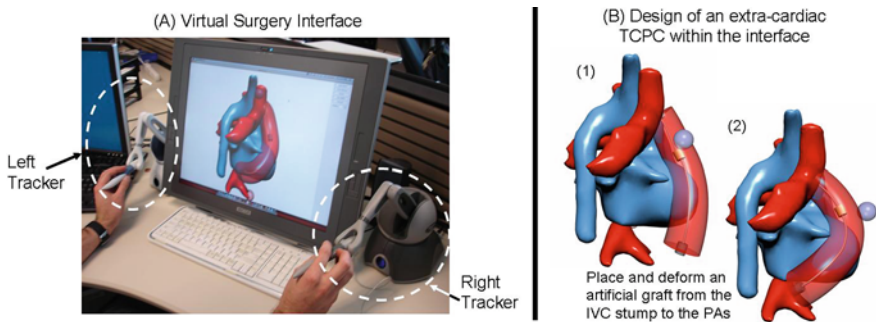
Example of a virtual surgery environment. Patient TCPC (*shown in red*) and surrounding anatomical structures, such as the heart and great vessels (*shown in blue*), have been reconstructed from MRI and loaded into the virtual surgical interface. Using two haptic trackers, one in each hand, the user/surgeon may directly interact with the geometry, here placing and deforming an artificial graft to complete the TCPC. (a) Virtual surgery interface. (b) Design of an extracardiac TCPC within the interface
